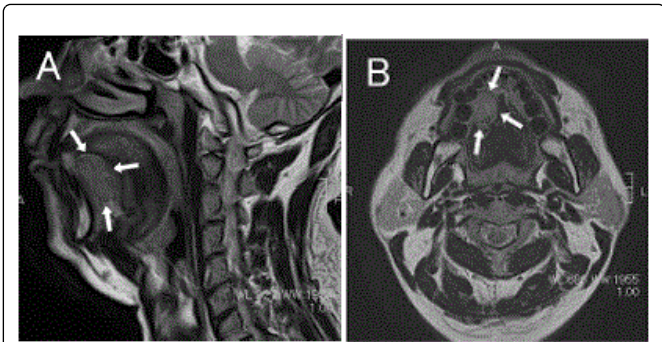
T2-weighted MR images showing a moderate-intensity mass at the right oral floor. Sagittal (A) and axial (B) views.
